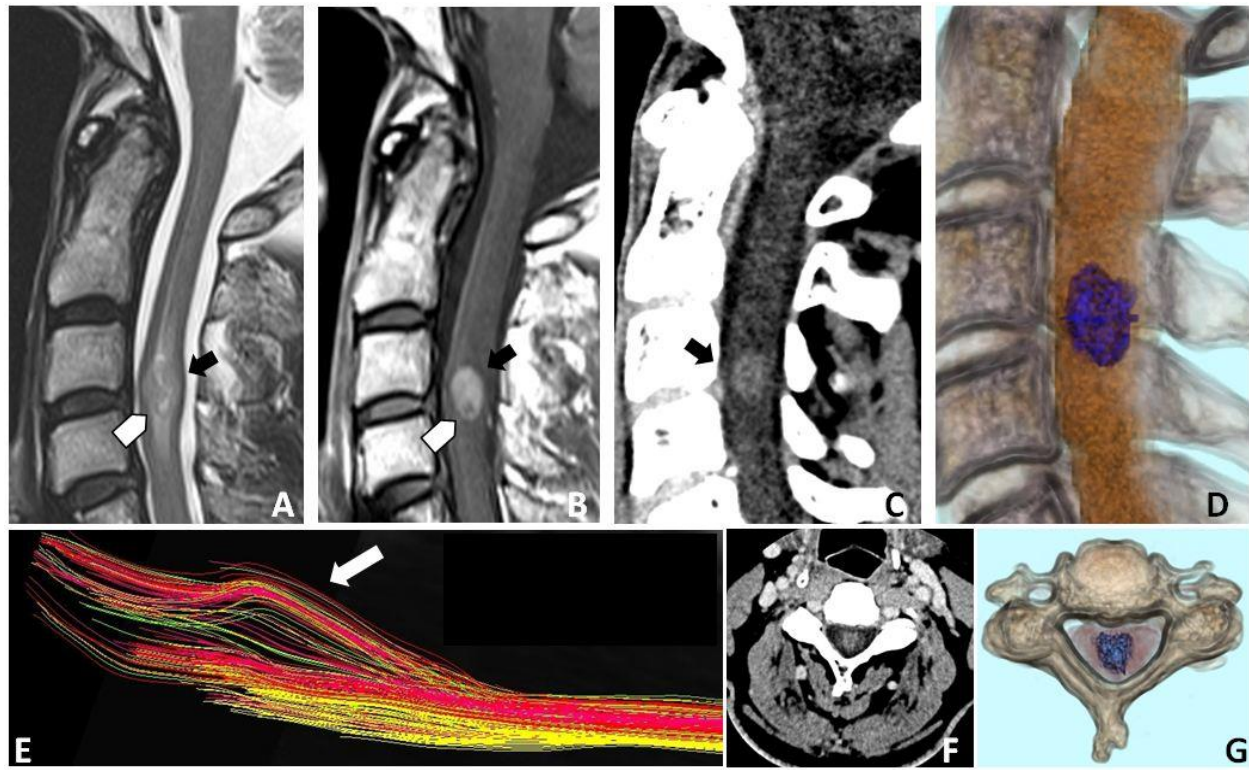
MRI and CT images of a spinal intramedullary ependymoma
